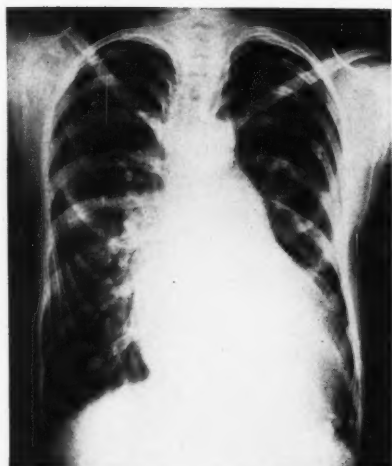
Chest x-ray. See description in text.
